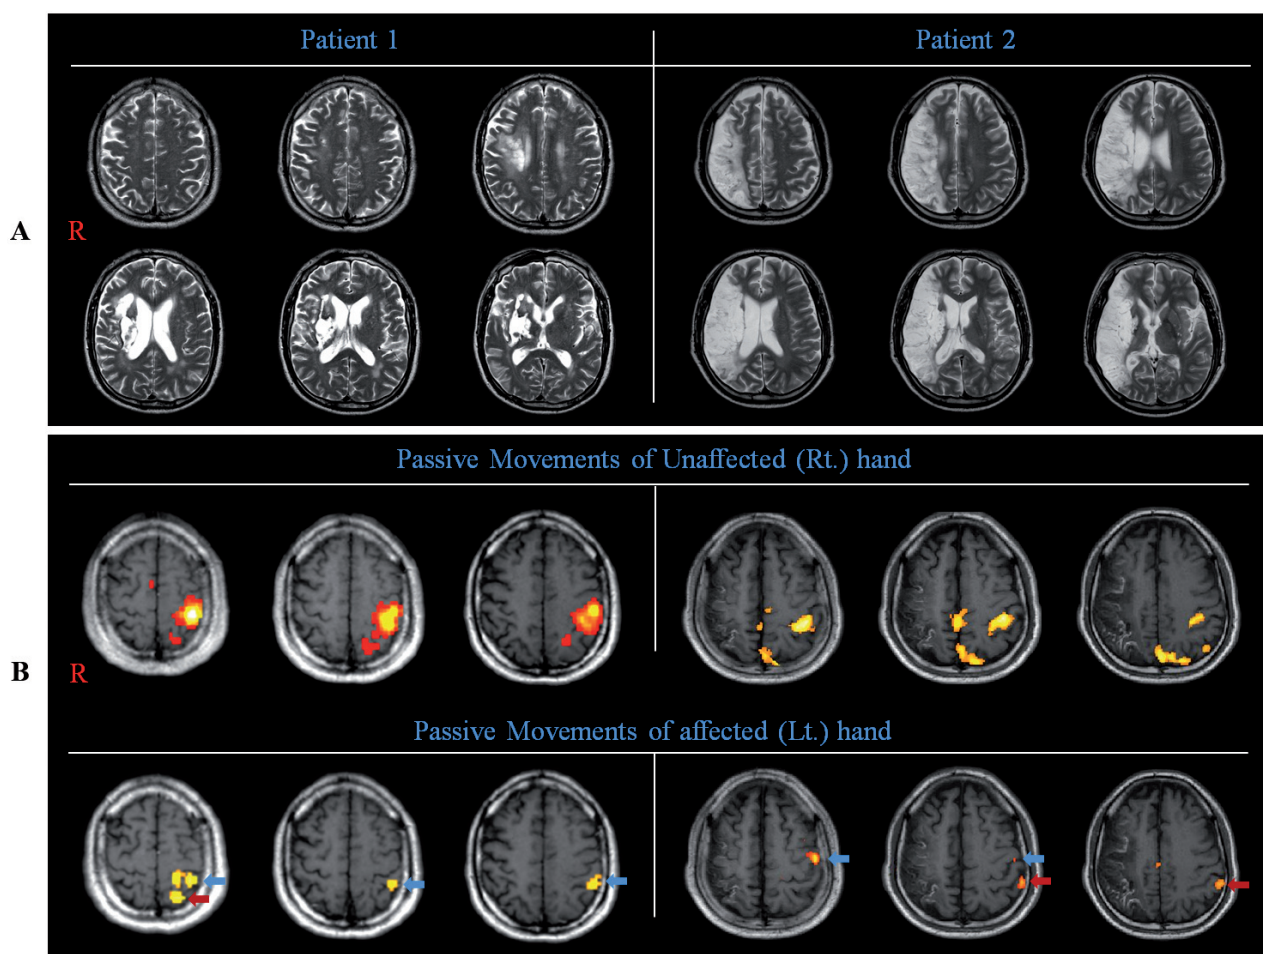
(A) T2-weighted images show a leukomalactic lesion in the right coronal radiata and basal ganglia (patient 1) and a right middle cerebral artery territory infarct (patient 2). (B) Results of functional magnetic resonance imaging. The left primary sensorimotor cortex (blue arrow) and posterior parietal cortex (red arrow) were found to be activated during passive movement of either hand.
